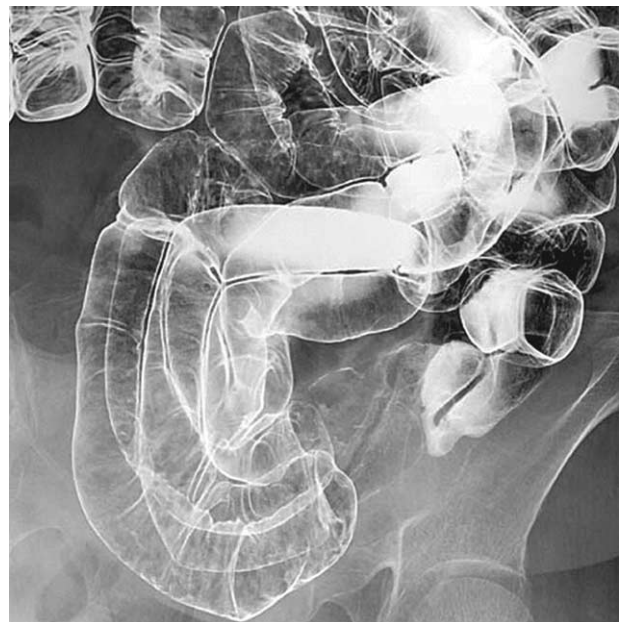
Small-bowel lesions of FAP. Double-contrast radiography demonstrates fine barium flecks and granular appearance in the ileum. FAP = familial amyloid polyneuropathy.
